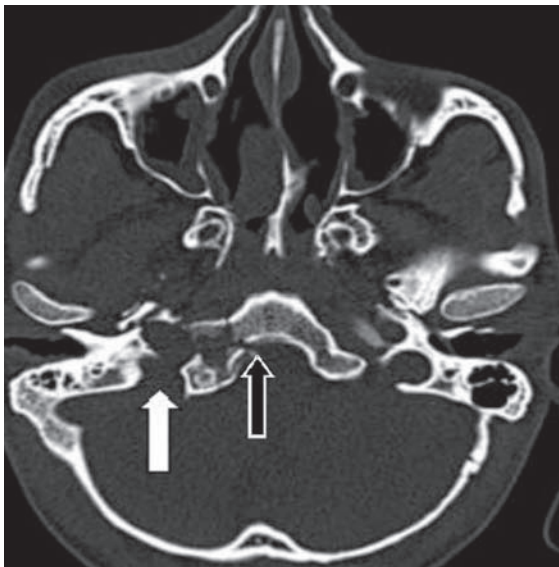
CT scan showing extensive disruption of the right jugular foramen (block arrow) and fracture of the clivus (empty arrow)
